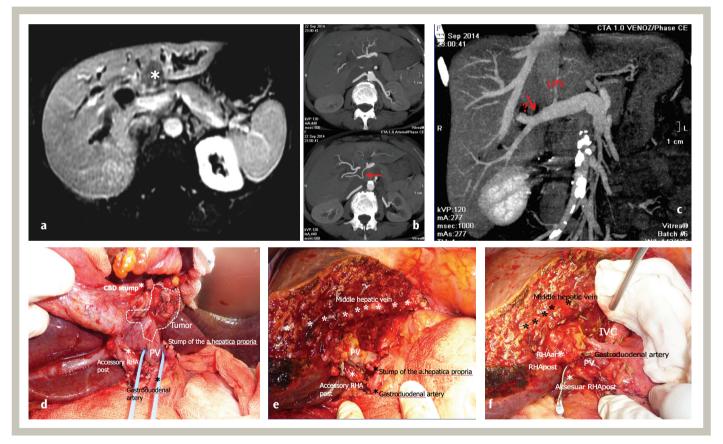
a) Perihilar cholangiocarcinoma (asterisk), b) Involvement of the left and middle hepatic arteries; there is an accessory right posterior hepatic artery (arrow). c) Encasement of the left portal vein branch, suspected involvement of the right branch (arrow). d) The right and left hepatic arteries, the posterior wall of the main portal vein and the left portal vein branch were involved; the accessory right posterior hepatic artery (RHA post) was not. e) Doppler USG showed arterial signals in the right posterior section only. The vascular clips are on the right anterior and posterior branches of the right hepatic artery, f) anastomosis to the branching area would entail risk of thrombosis; the right anterior hepatic artery was reconstructed using the gastroduodenal artery (arrow)
